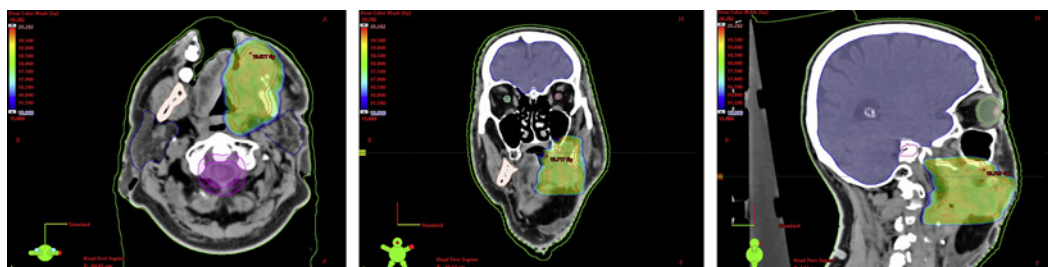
Stereotactic RT. Dose distribution is shown on the CT scan.
